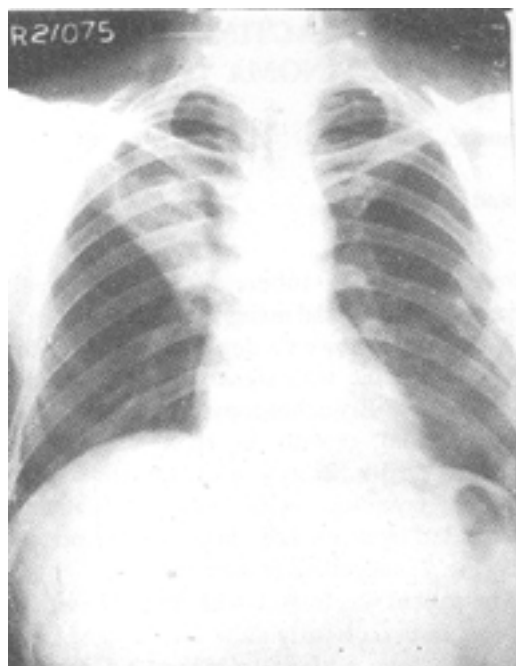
X-ray chest showing dense opacity over right upper zone with signs of loss of volume, with evidence of healed fracture 5th, 6th and 7th posterior ribs on the left side
